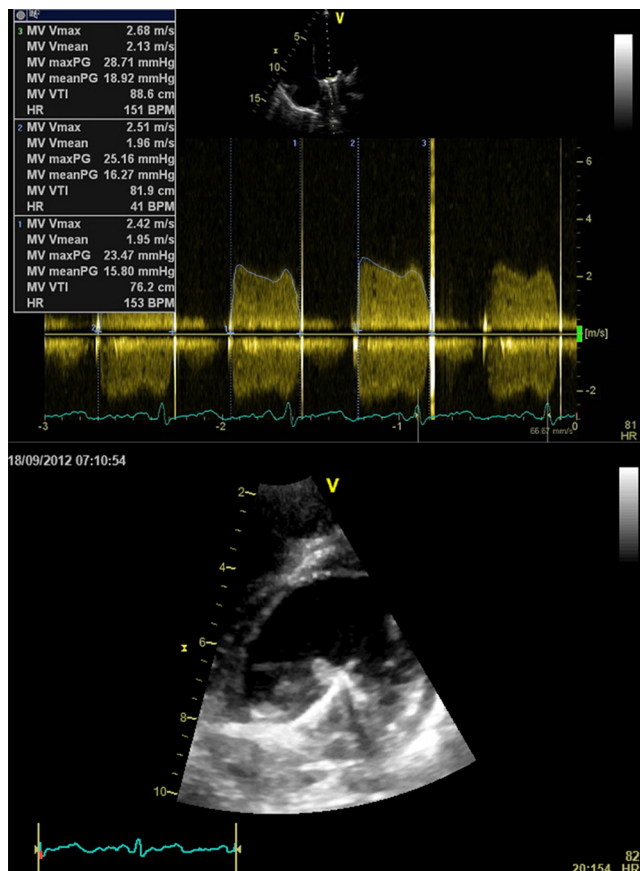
Transesophageal echocardiogram of the thrombosis of the prosthetic valve in mitral position.
